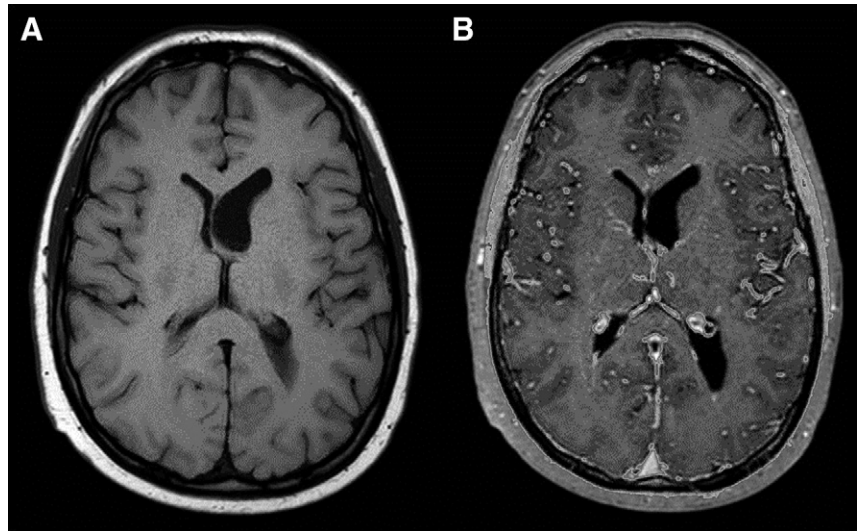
Post-treatment axial (A) noncontrast and (B) contrast enhanced magnetic resonance imaging of patient 1.
